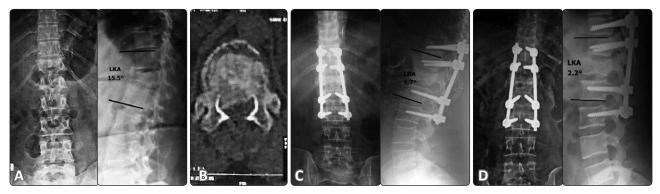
Male patient, 31 years old, with A3 fracture of T12. He was treated by long-segment fixation from T10 to L2. Preoperative (A) plain X-rays (LKA 15.5°, AVHL% 30.7%); (B) CT scan. Postoperative (C) plain X-rays (LKA 1.7°, AVHL% 10.2%); (D) final follow-up plain X-rays (LKA 2.2°, AVHL% 12.8%).
